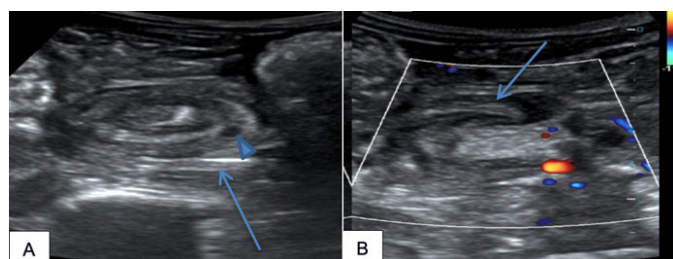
Ultrasound showing a bowel mass with several images of “bull's eye” (blue arrowhead) and “railway track” (blue arrow) suggestive of intestinal ascariasis. (A) Transverse section showing a bowel mass like a doughnut. (B) Longitudinal scan showing a bowel mass like a sandwich.
